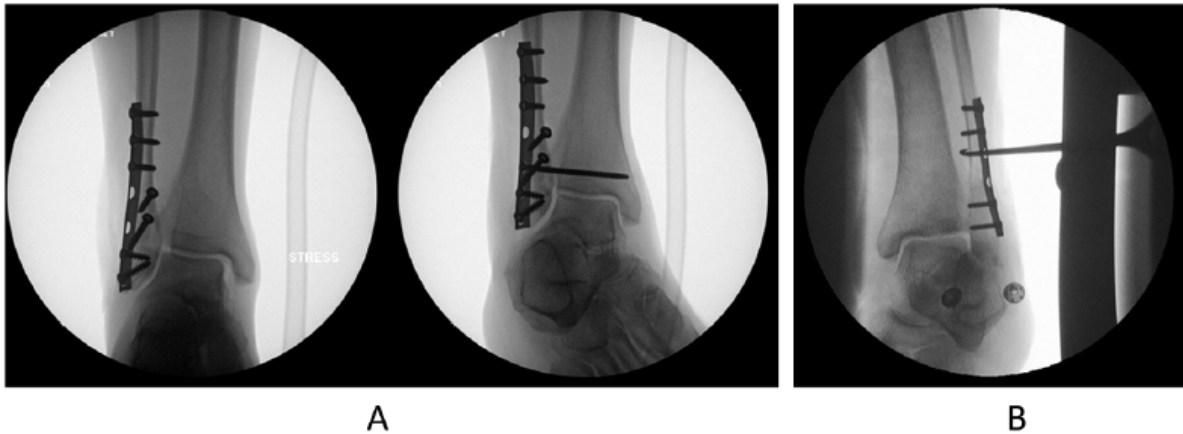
(A) Intraoperative fluoroscopy of ankle fixation. Left: Stress radiograph following fixation of a Weber B fibula fracture with medial clear space widening. Right: Radiograph following syndesmotic screw fixation. (B) Hook test performed in which the fibula is pulled lateral to assess for medial clear space widening.
